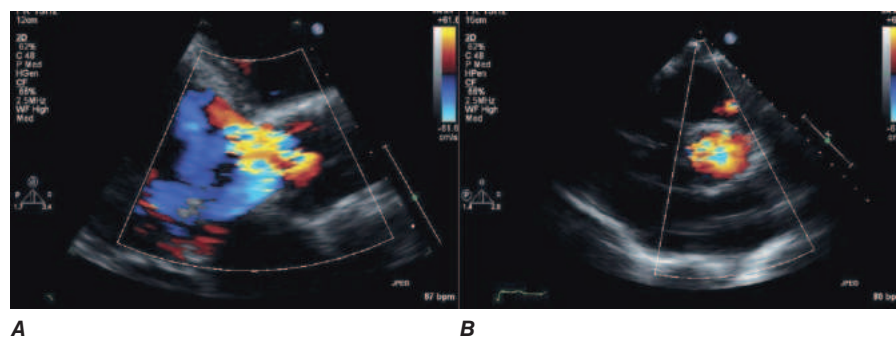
Aortic regurgitation visualized by color flow Doppler in the parasternal long-axis view (A) and the parasternal short-axis view (B).
